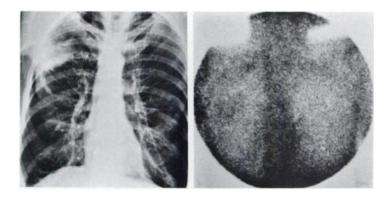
Histoplasmosis. Peripheral opacity in right upper lobe (left). Tc-GHA image shows ill-defined 1+ uptake in area corresponding to opacity noted on chest radiography (right).
